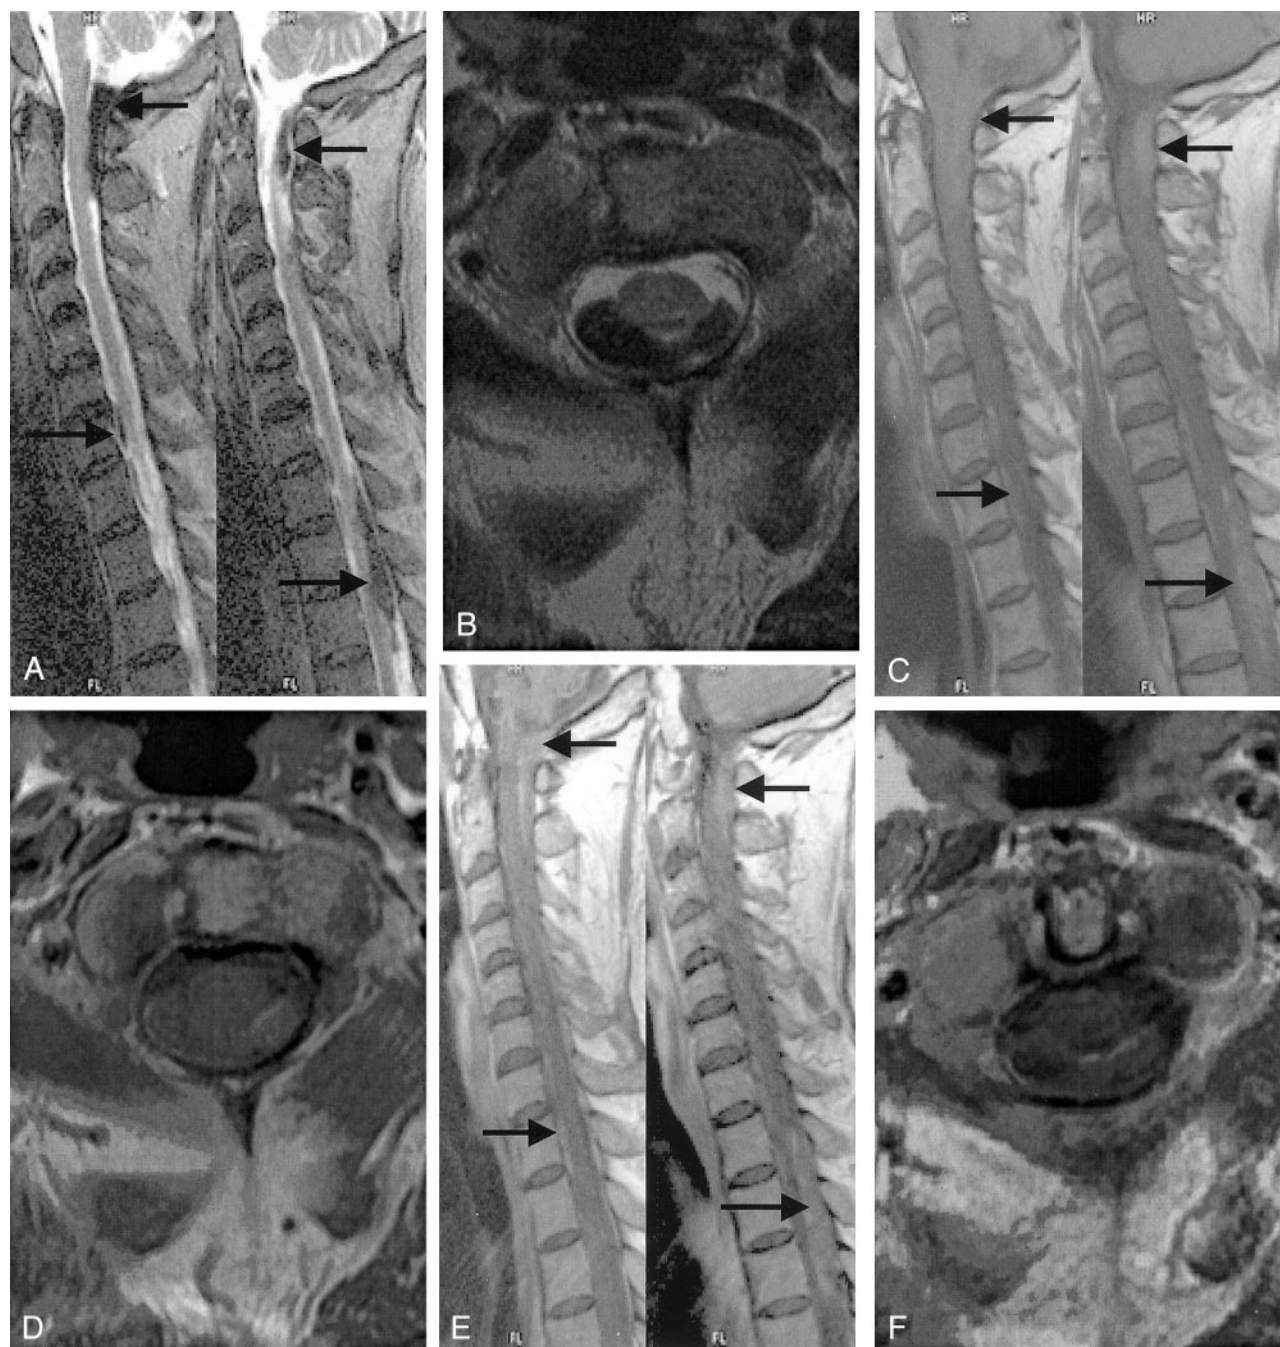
MR images show two dural soft-tissue masses (*arrows*) located at the cervical and thoracic (C1–C2 and T1–T4, respectively) levels. The dural soft tissue masses caused indentation to the spinal cord without prominent cord compression. They wrapped around the spinal cord, especially posteriorly at the cervical level and left posterolaterally at the thoracic level. These lesions are minimally hyperintense to spinal cord on T1-weighted MR images and prominently hypointense on T2-weighted images. Contrast-enhanced MR images reveal no prominent enhancement in these lesions except minimal peripheral enhancement. No abnormal signal intensity is present in the spinal cord on the T2-weighted images at the level of the lesions. At the lower cervical and upper thoracic levels, minimal anterior dural thickening with the same signal intensity features of dural masses on the C7–T1–T2 levels are also noted (*arrow*).
